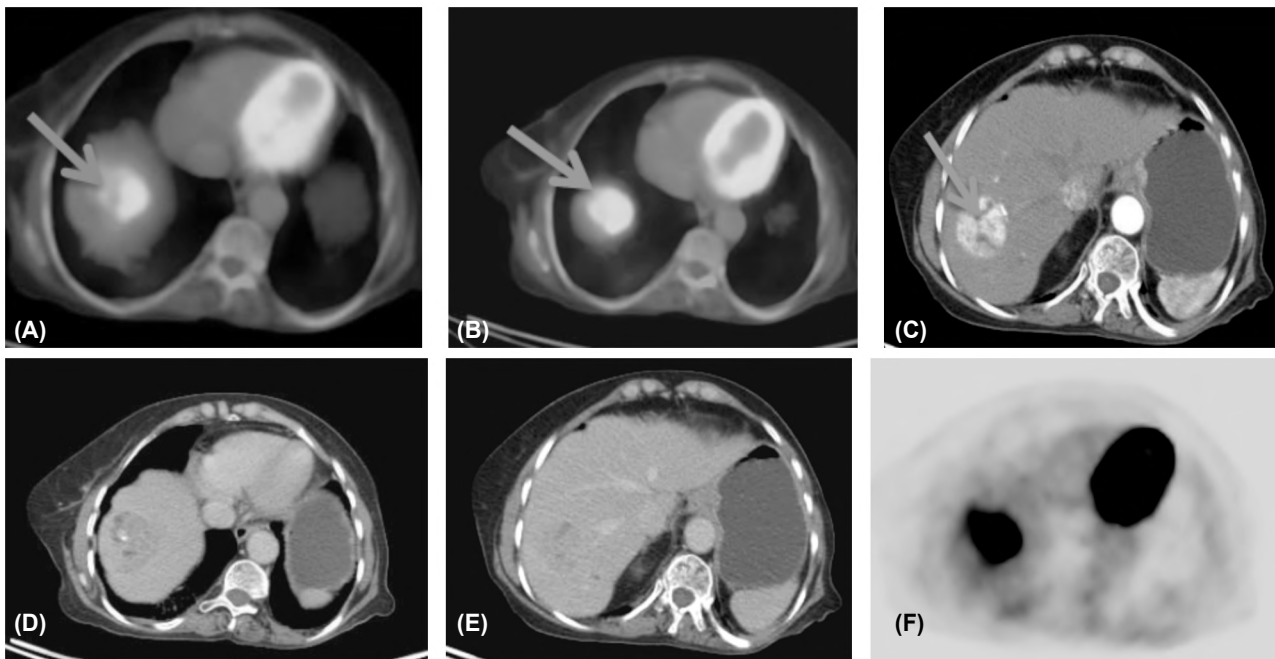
PET/CT and triphasic CT images of 67 years old female patient show (A,B,F) PET/CT images showing a metabolically active lesion (red arrow) measuring about 5x5.5 cm, achieving SUVmax of 14.08 and SUVratio of 1.62, (C) triphasic CT showing lesion with early arterial heterogeneous enhancement (blue arrow), (D,E) The lesion shows rapid washout in portovenous and delayed images.
